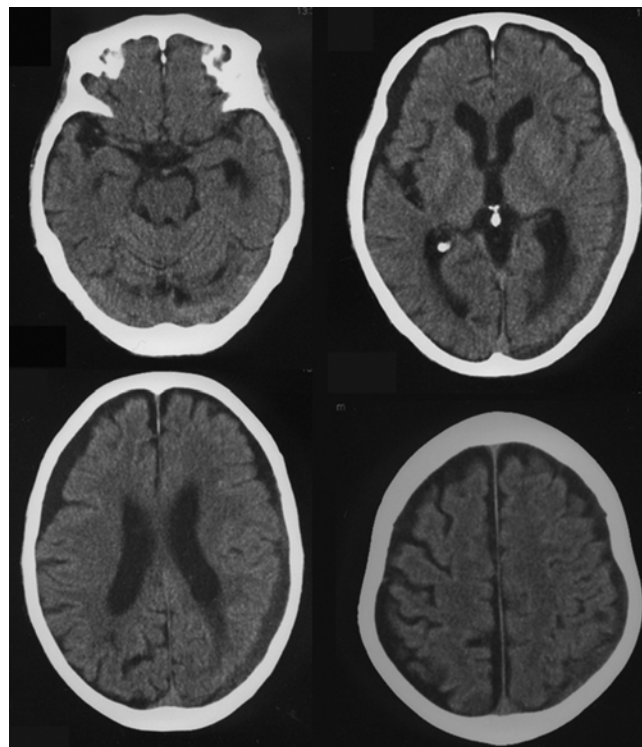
Case 13. CT images at 4 months after starting tranexamic acid therapy.
